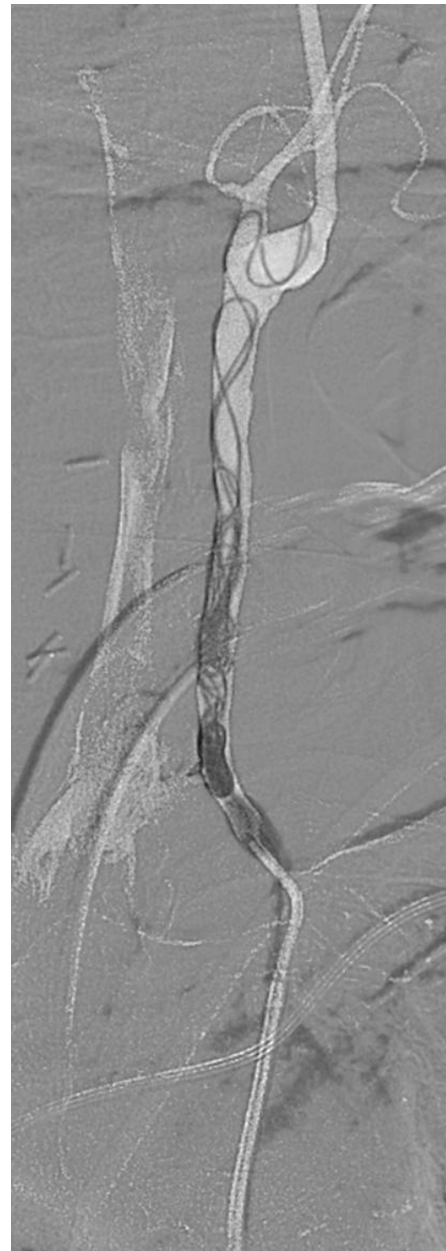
CTA of the left common carotid artery post embolization and coiling showing successful hemostasis.
